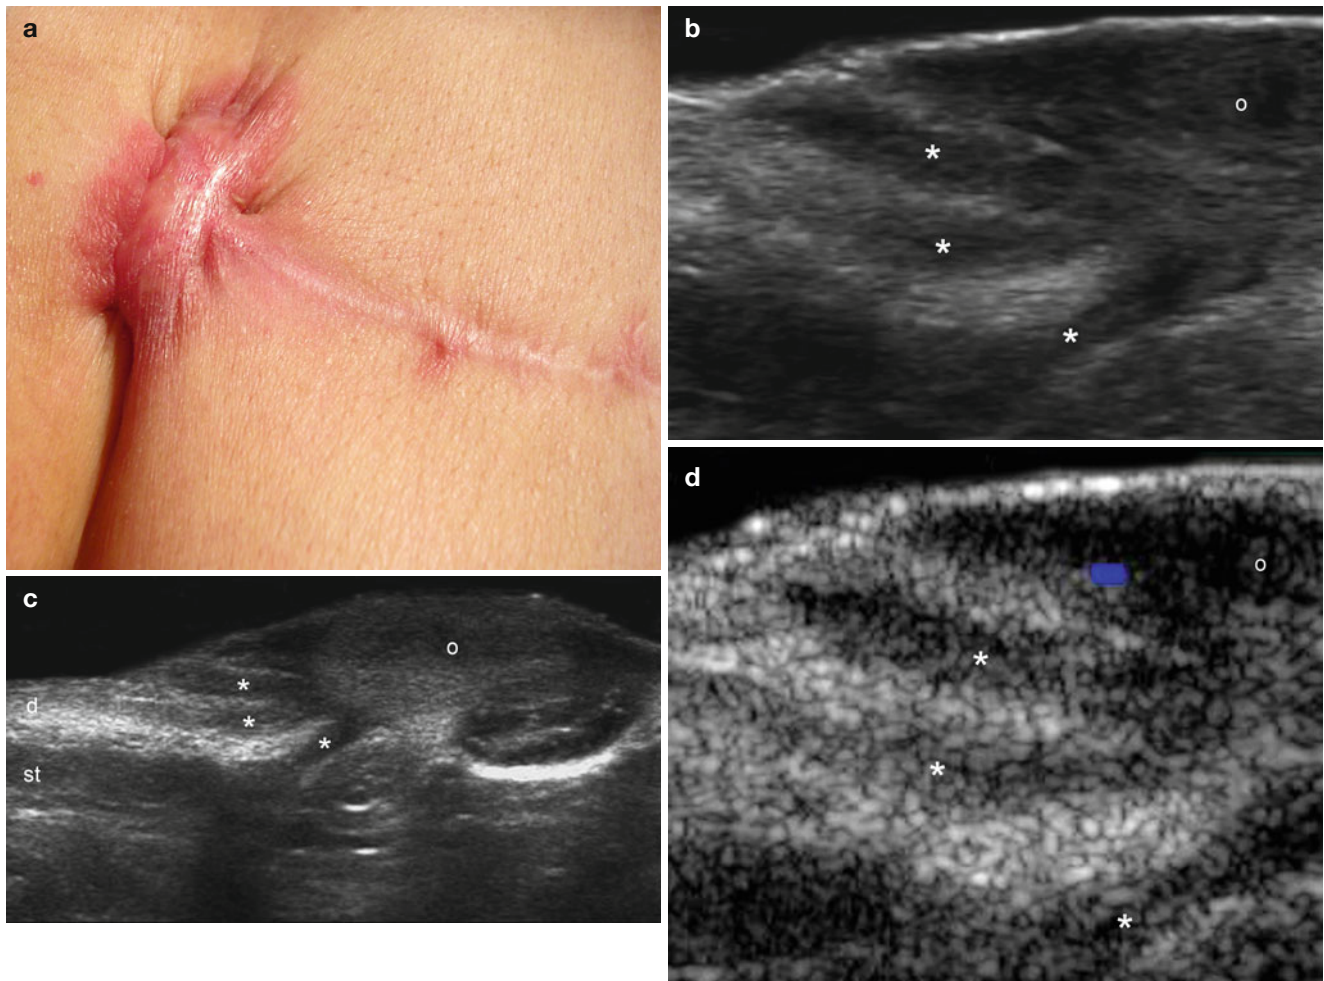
(a–d) Keloid. (a) Clinical image shows an erythematous lump in the upper part of a scar in the abdominal wall. (b, c) Grey scale ultrasound images (b zoomed and c extended field of transverse views) demonstrate an oval-shaped hypoechoic lesion (o) located in the dermis
